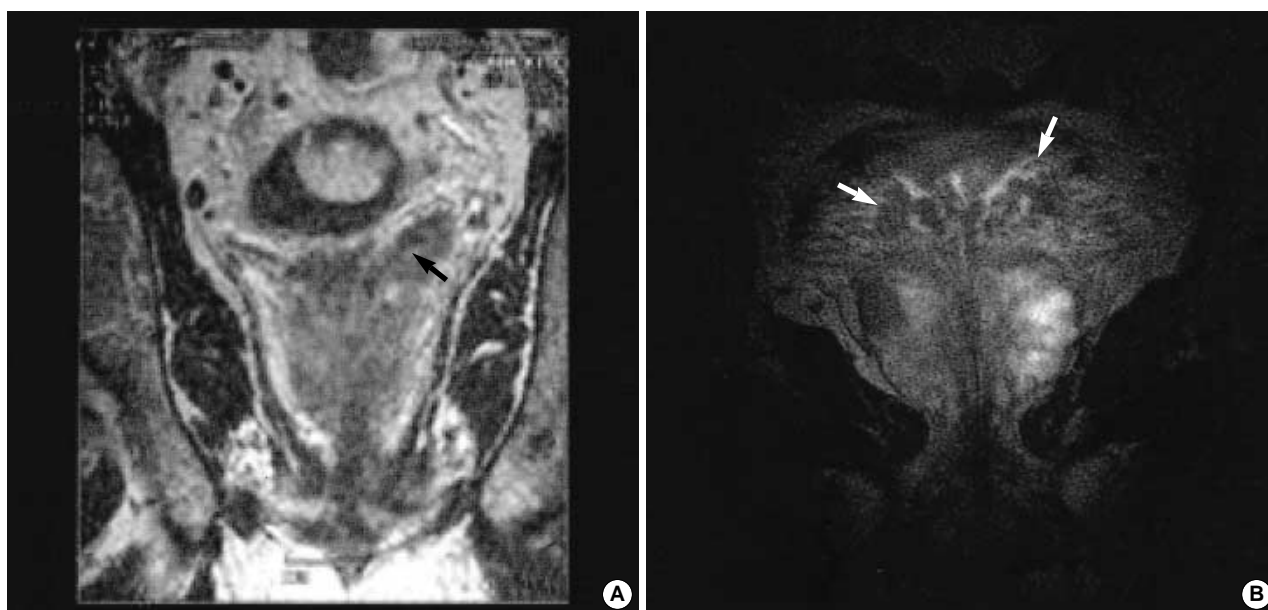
Multiple irregular foci of low signal intensity are observed in the prostate as well as in the area of both seminal vesicles and vasa deferentia (arrow) on the T2-weighted MR imaging, suggesting tumor extension of prostatic carcinoma to the seminal vesicles and vasa deferentia. (A) Case 1. (B) Case 2.
